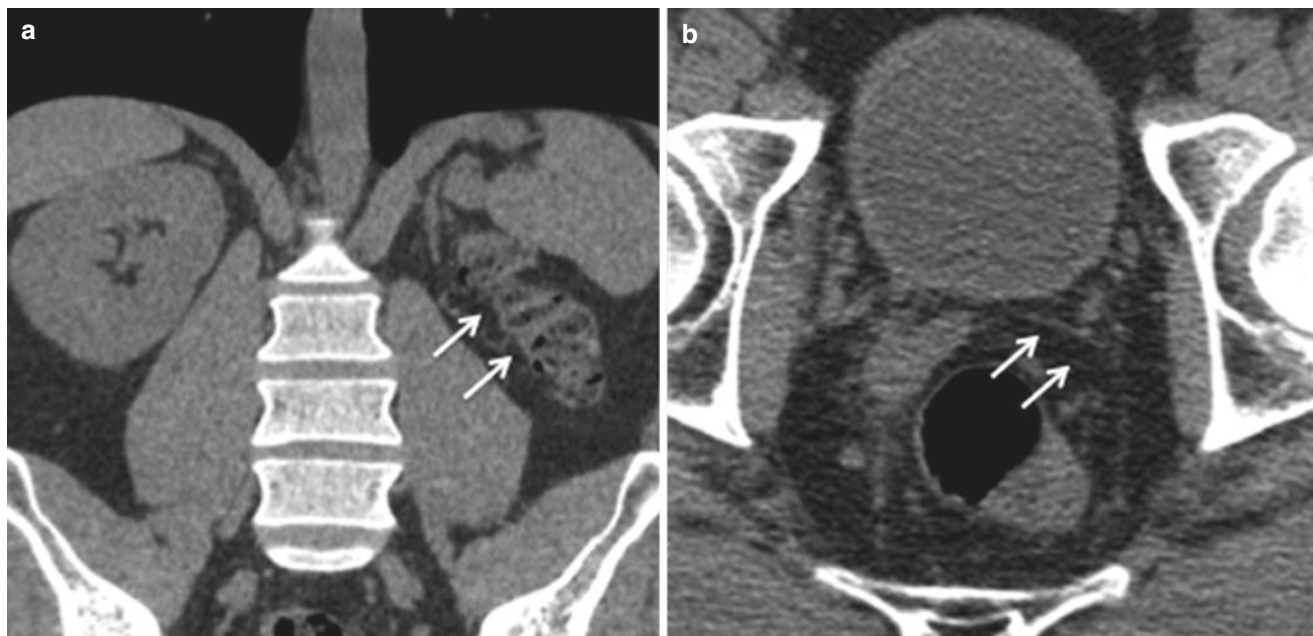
Agenesis of the SV and of the kidney in a 32-year-old man with infertility. CT image in the coronal (a) and axial (b) shows left renal agenesis (arrow) and ipsilateral absence of the SV (arrows)
